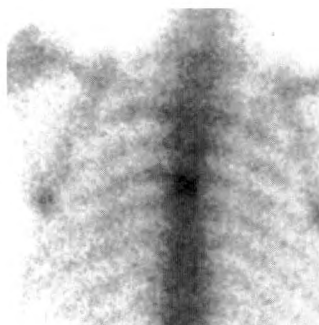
The technetium-99m phosphonate bone scan revealed a single abnormal area of uptake in the T6 vertebral body. Plain radiographs and a CT scan of the same area were negative.
